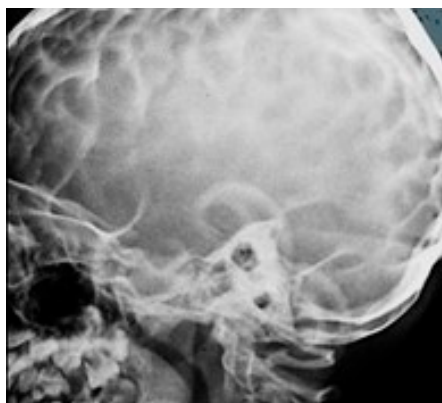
Skull X-ray (lateral view) showing beaten-silver/beaten-copper appearance due to chronic raised ICP. Source: Figure by authors.
